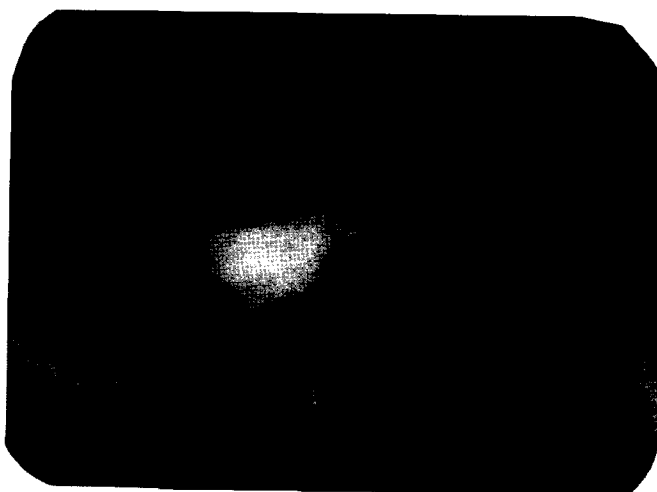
Intraoral periapical radiograph taken after 1 month.
